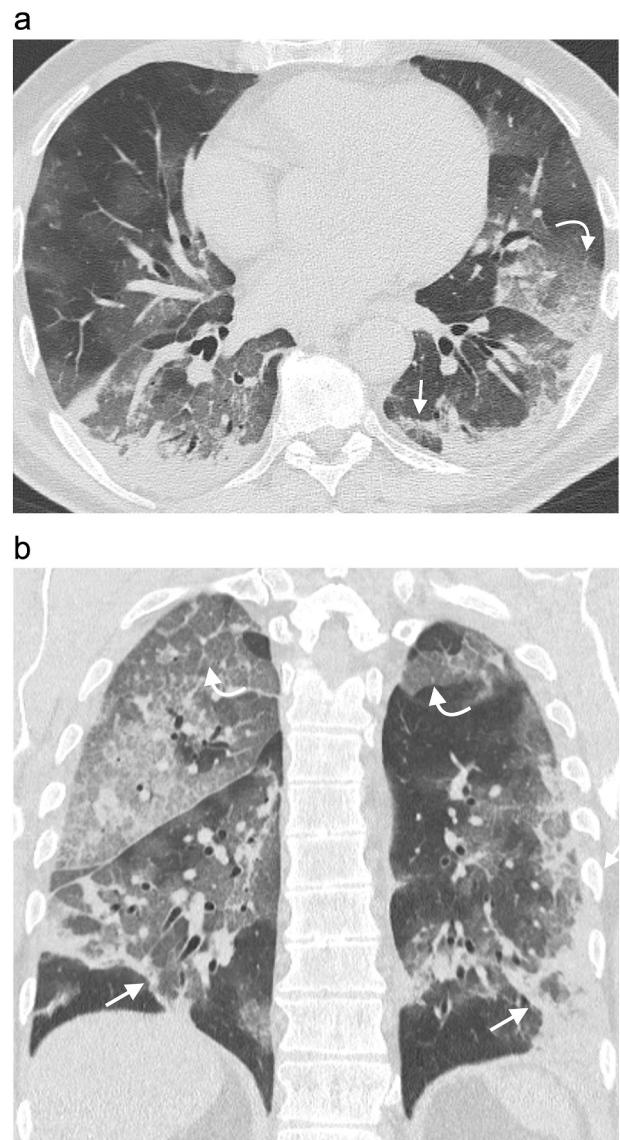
COVID-19 pneumonia with severe disease extent in a 62-year-old male patient. HRCT images on the axial (a) and coronal (b) planes show bilateral, multifocal ground-glass opacities, along with subpleural consolidations in the lower lobes and areas of crazy-paving pattern in the upper lobes (*curved arrows*). Perilobular consolidations and band-like opacities are also visible, resembling an organizing pneumonia pattern (*straight arrows*). Computed tomography involvement scores were 16/24 for radiology resident 1, 17/24 for radiology resident 2, and 21/24 for the chest-devoted radiologist. All the readers defined the appearance as “typical” according to the Radiological Society of North America categorization. The patient was hospitalized and admitted to the intensive care unit.
